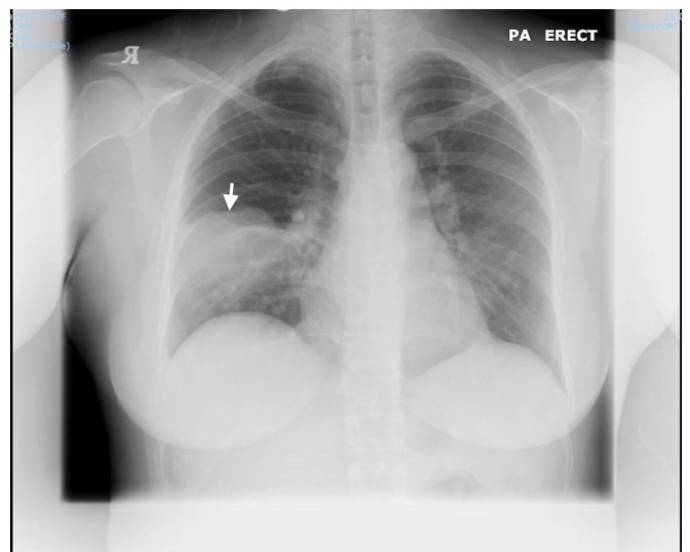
Chest X-ray showing a round mass like opacity in the right middle and lower zones.
